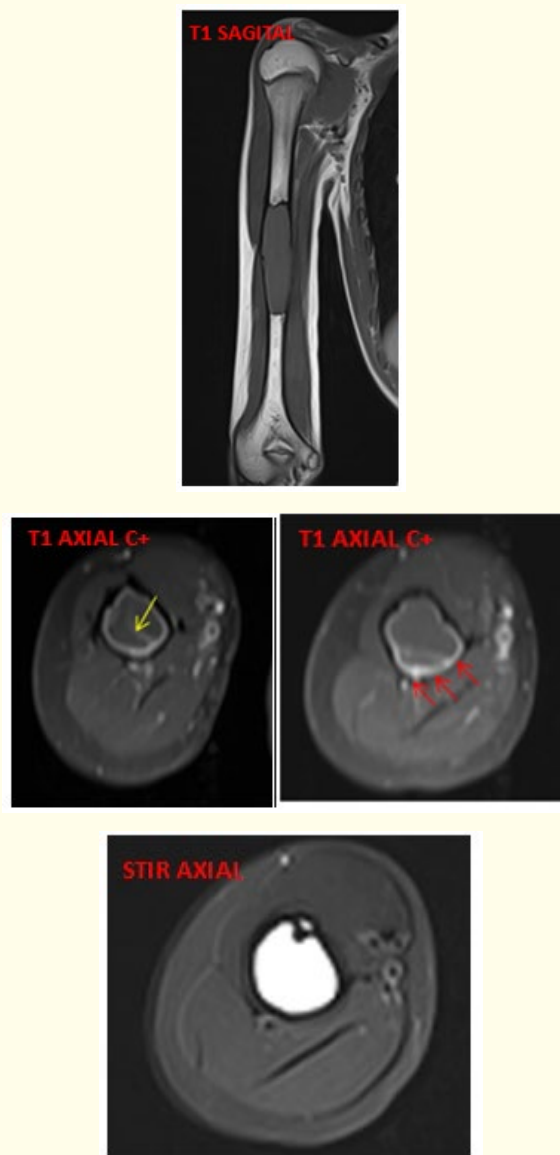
MRI images depicting the intramedullary lesion in the right humerus, which was previously mentioned in detail.
